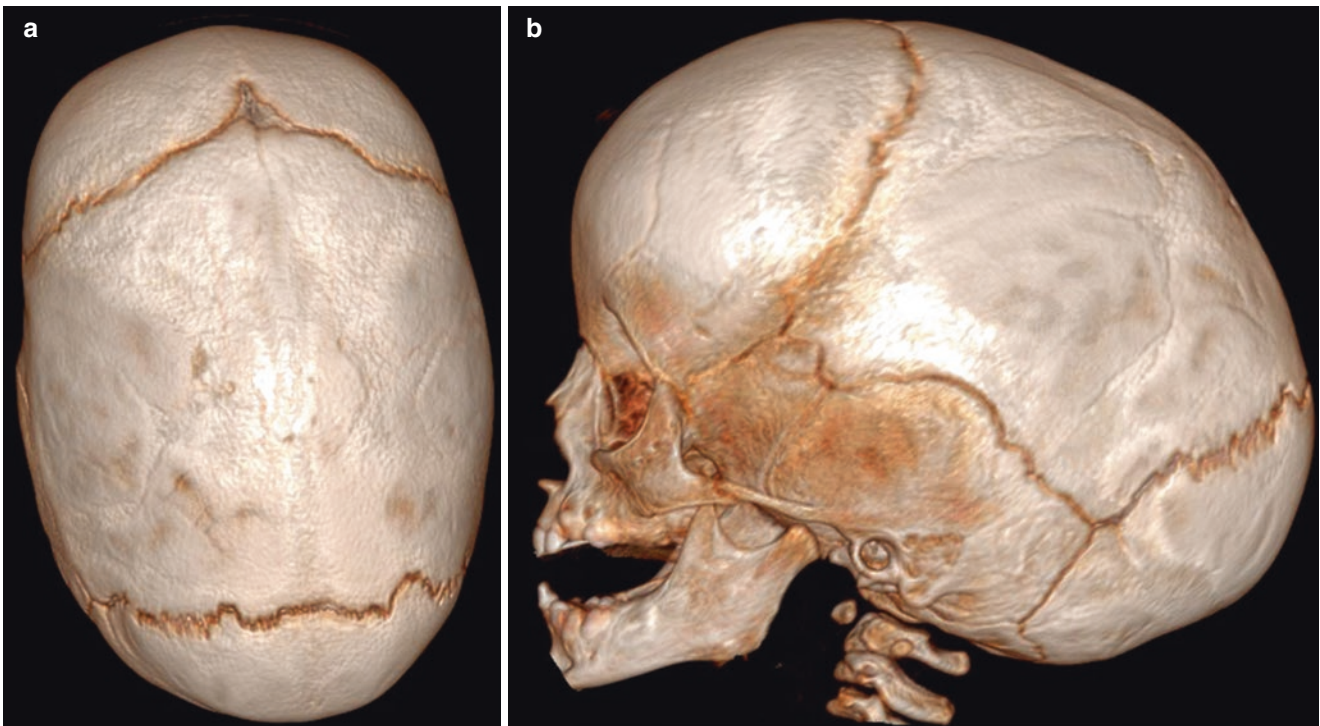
3D reconstructed CT images of skull showing prematurely fused sagittal suture (a) and scaphocephaly (b)
